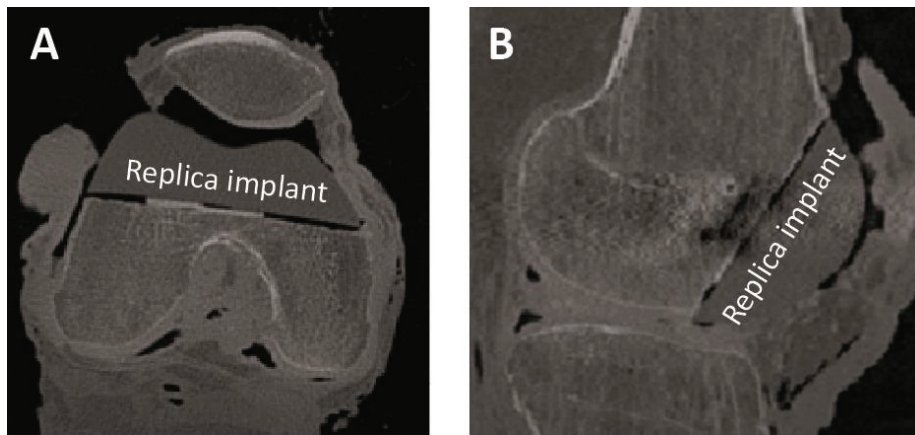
Post-operative CT scan: axial and sagittal view on the cutting plane.
